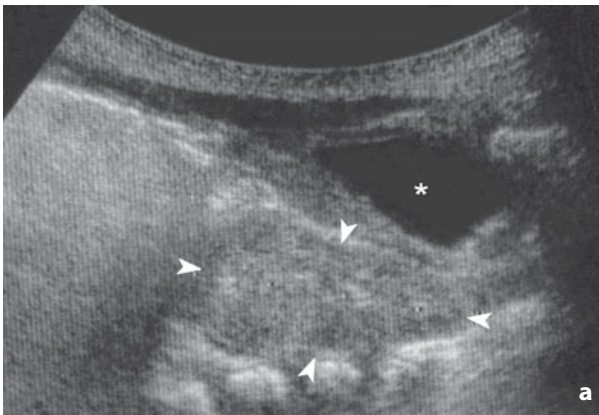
Simple renal ectopia. a Longitudinal sonogram shows the kidney located in the pelvis (*arrowheads*) posterior to the urinary bladder (*asterisk*) and anterior to the lumbar vertebrae. b Voiding cystourethrography shows vesicoureteric reflux and confirms the left simple renal ectopia located in the pelvis
